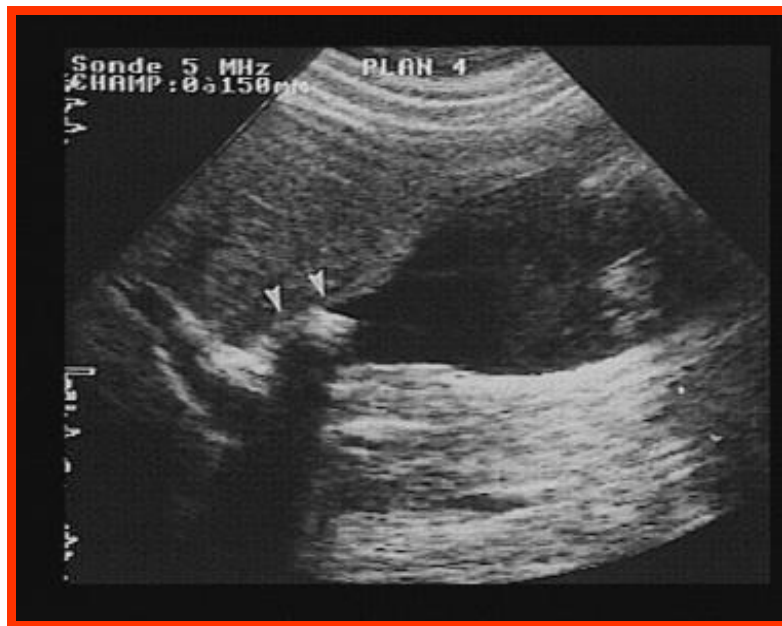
Patient M., 63 years old. Sonogram. Enlarged gallbladder.
